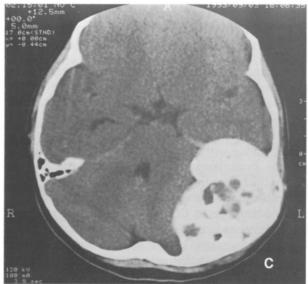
The CT appearance of the lesion with and without contrast demonstrates partial blockage of the external acoustic meatus and narrowing of the tympanic cavity and internal ear canal (a,b), and tumor invasion to the level of the middle fossa and preportine angle (c).
